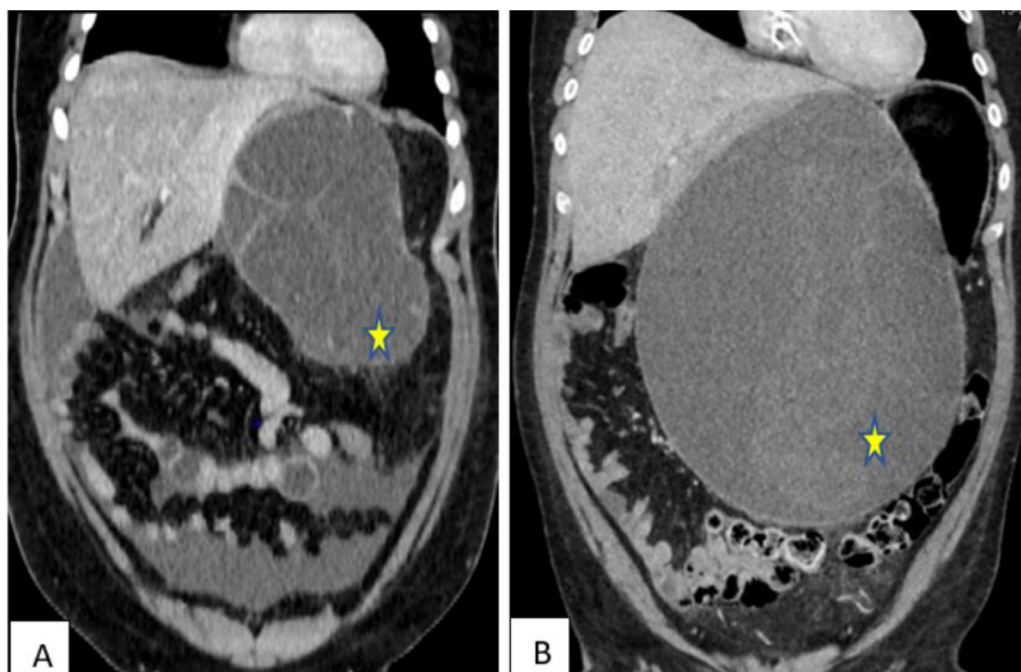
Coronal plane CT at the time of diagnosis (A) and 6 months later (B) demonstrating the tumor increases in size rapidly, growing downwards (star sign, B), this is a sign that the tumor responds poorly to treatment, poor prognosis.
